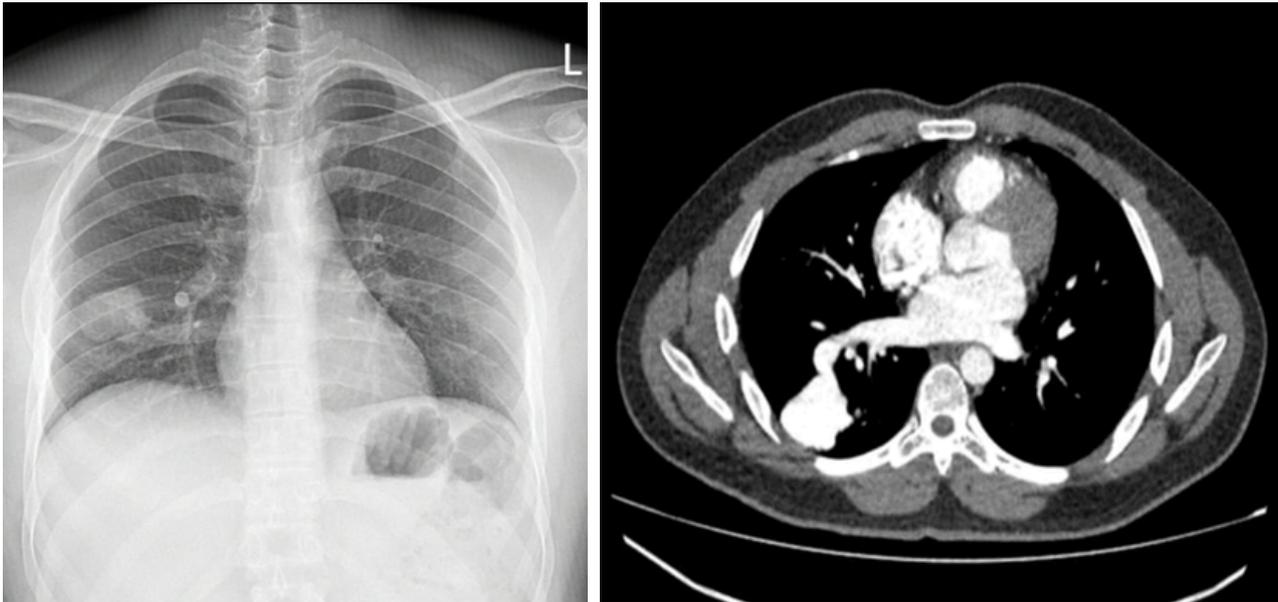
Chest x-ray shows a heterogenous mass like lesion in right lower zone and CTPA shows a pulmonary arteriovenous malformation
